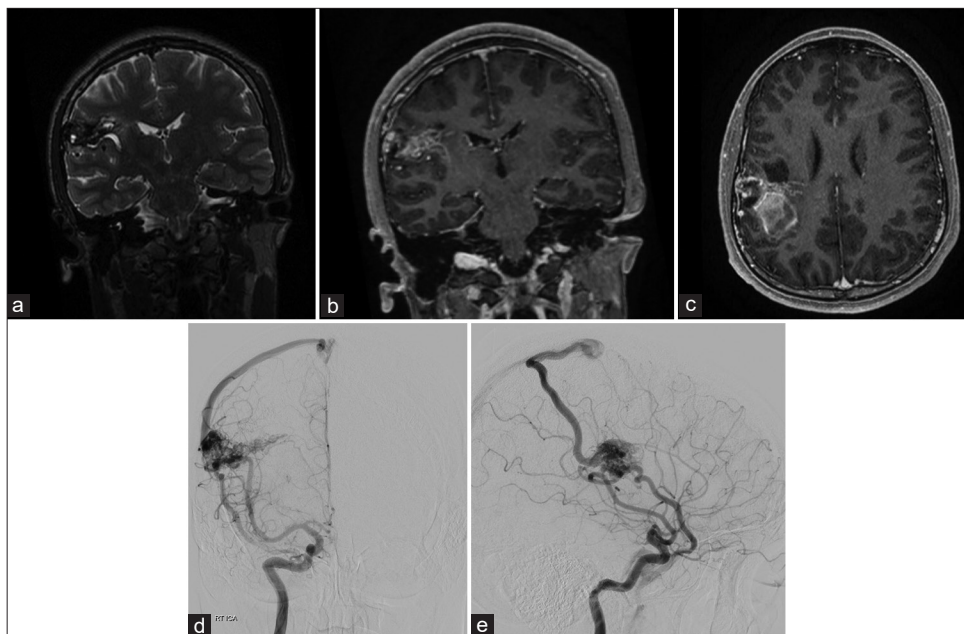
Preoperative imaging of the right frontal arteriovenous malformation. (a) Magnetic resonance imaging (MRI) T2-weighted Coronal view, (b) MRI T1-weighted with contrast, Coronal view, (c) MRI T1-weighted with contrast, axial view, and (d and e) digital subtraction angiography shows the nidus supplied by the right middle cerebral artery and with early draining into the superior sagittal sinus in the arterial phase.
